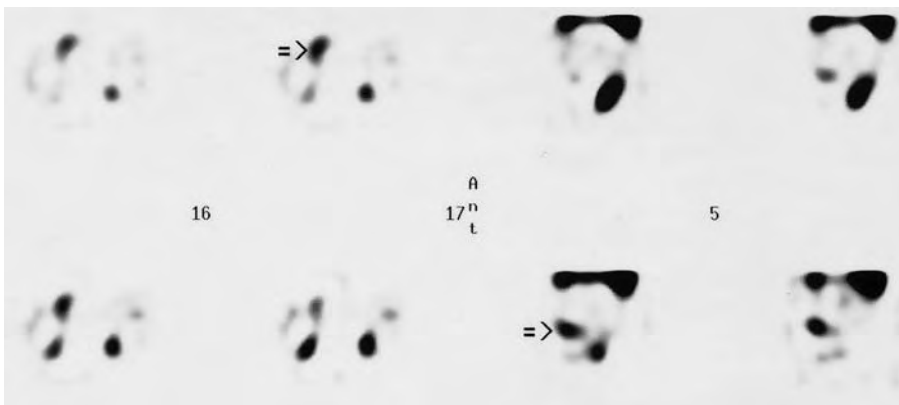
^{123}I -VIP receptor scintigraphy indicates the primary colorectal tumor (arrow) 2 h after injection of 1 μg (150 MBq) radioligand with single photon emission computed tomography (SPECT); four images in left panel (16, 17): transverse reconstruction; four images in right panel (5): sagittal reconstruction
